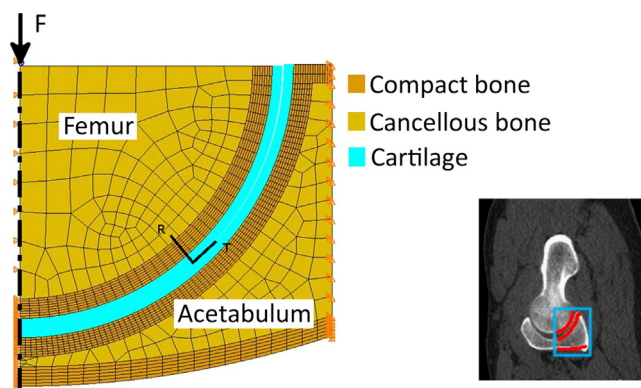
The generic axisymmetric model of the hip was based on the cross section in the oblique sagittal slice of a computed tomography scan, outlined in blue (right). The compact bone layers are highlighted in red. The material properties were assigned for each region identified. A time-varying cyclic force, F , was applied to the femoral head. Fibril preferred stiffness directions are defined relative to the locally radial (R) and tangential (T) directions of the cartilage tissue shown by the black lines (left). (For interpretation of the references to color in this figure legend, the reader is referred to the web version of this article.)
